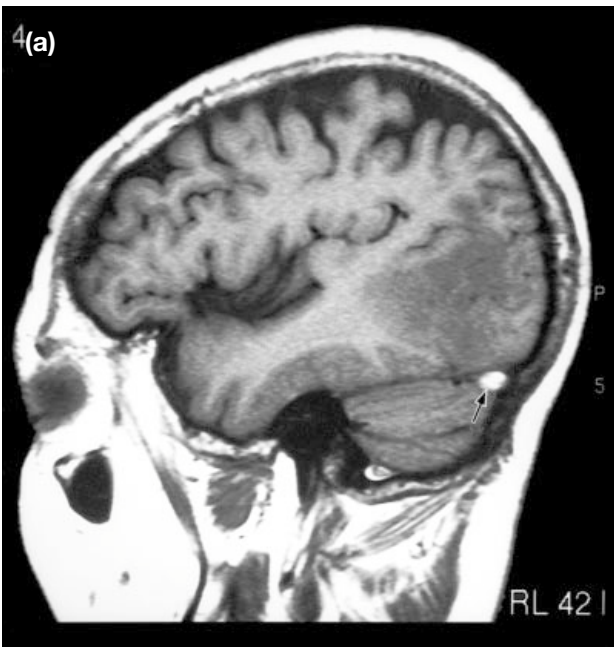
Three days after presentation. Sagittal T1-weighted image (a) and axial T1-weighted image (b) showing loss of the normal flow void in the left transverse sinus (arrow) and effacement of the adjacent sulci.
